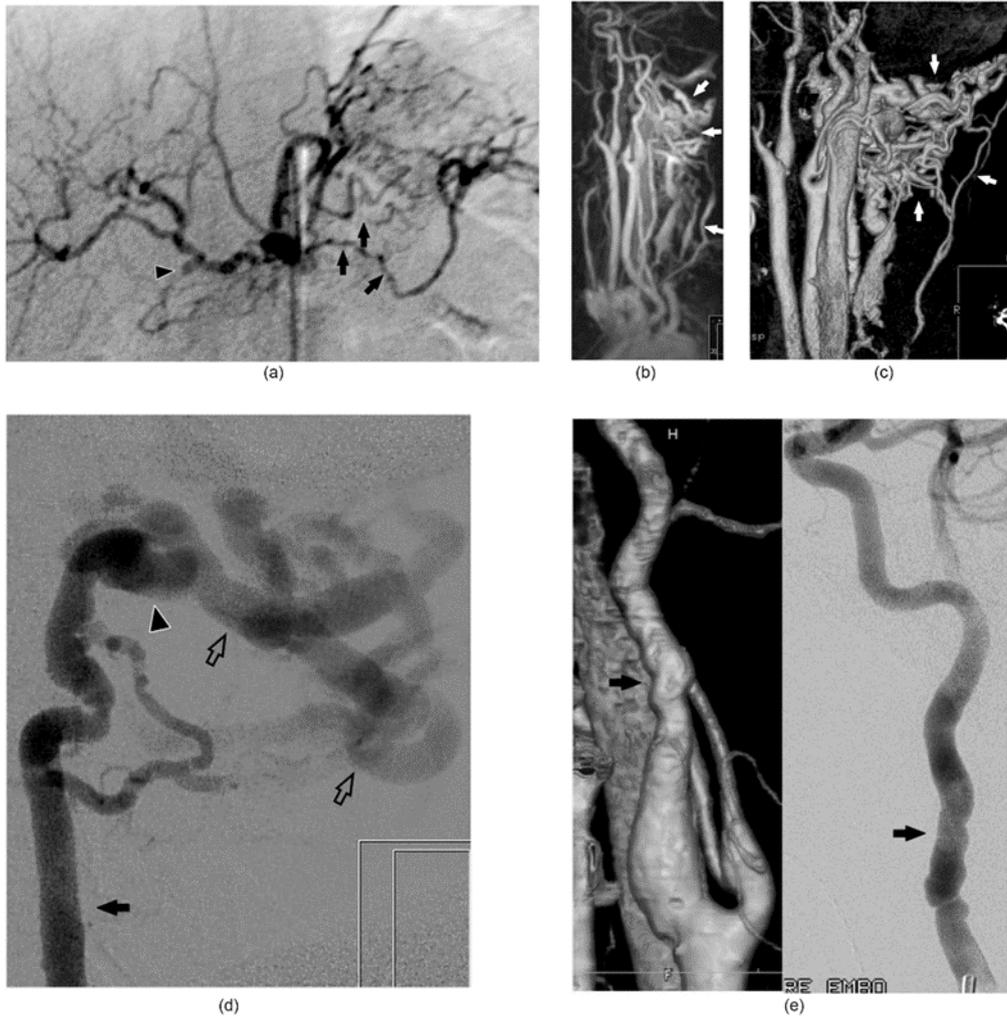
(a-e). Polyarteritis nodosa. (a) CA of the celiac axis performed five years prior to presentation with multifocal luminal narrowing (black arrows) and aneurysmal dilatation of the hepatic and splenic arteries (black arrowhead). (b and c) MRA and CTA reveal a collection of prominent, tortuous vasculature at the posterior cervical space enveloping the distal left vertebral artery. Prominent draining veins are noted (white arrows). (d) The left vertebral artery (black arrow) is the site of arteriovenous shunting (black arrowhead) into a dilated, tortuous draining vein confirming the diagnosis of an arteriovenous fistula. (e) CTA and CA (left and right respectively) demonstrate a discrete region of luminal irregularity and narrowing within the proximal cervical segment of the internal carotid artery (black arrows) which in isolation could be confused with fibromuscular dysplasia. Abbreviations: CA, catheter angiography; MRA, magnetic resonance angiography; CTA, computed tomographic angiography. Courtesy of Adam Davis, MD.
